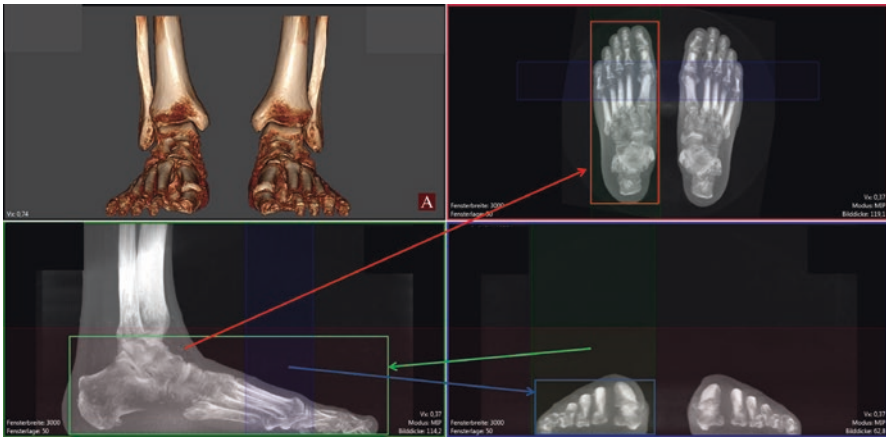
WBCT software screen view with increased slice thickness to create virtual radiographs. Top right, in red frame, virtual dorsoplantar radiograph created by increased slice thickness that contains entire foot (red arrow). Bottom left, in green frame, virtual lateral radiograph created by increased slice thickness that contains entire foot (green arrow). Bottom right, in blue frame, virtual metatarsal head skyline view radiograph created by increased slice thickness that contains the metatarsal heads (blue arrow)
